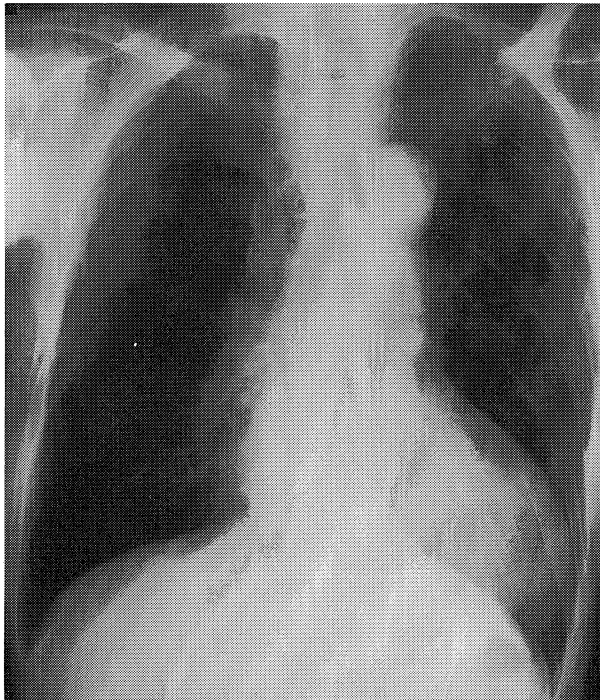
Chest radiography on admission. The chest radiography showed cardiomegaly (cardiothoracic ratio=60%), but no pulmonary edema.
